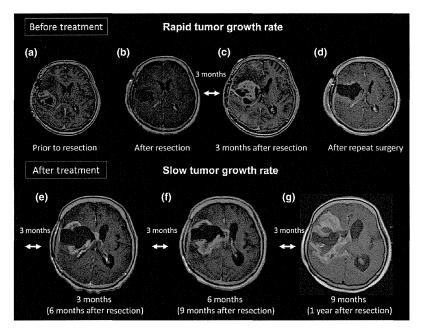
Serial magnetic resonance image of a patient who showed a rapid progression. The patient recurred within 3 months and repeated surgery was performed. Karnofsky performance scale at recurrence was 60%. After repeated surgery only the HUVEC vaccine therapy was continued. The tumor kept growing, but the tumor growth speed seemed to be slowed by the HUVEC vaccine therapy.
